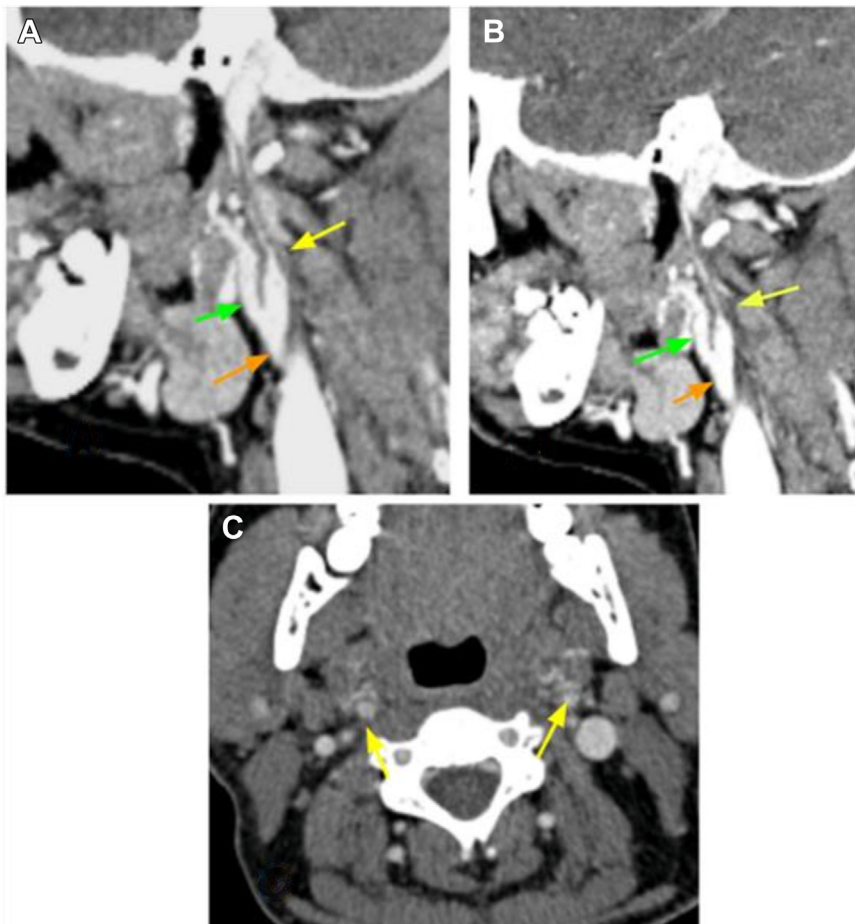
Computed tomography angiography (CTA) showing both hypoplastic internal carotid arteries (ICAs). Sagittal CTA showing stenosis in the right ICA (A; yellow arrow) and left ICA (B; yellow arrow), which begins above the level of carotid bulb. C, Axial CTA showing both hypoplastic ICAs (yellow arrows). Orange arrow indicates common carotid artery; and green arrow, the external carotid artery.
